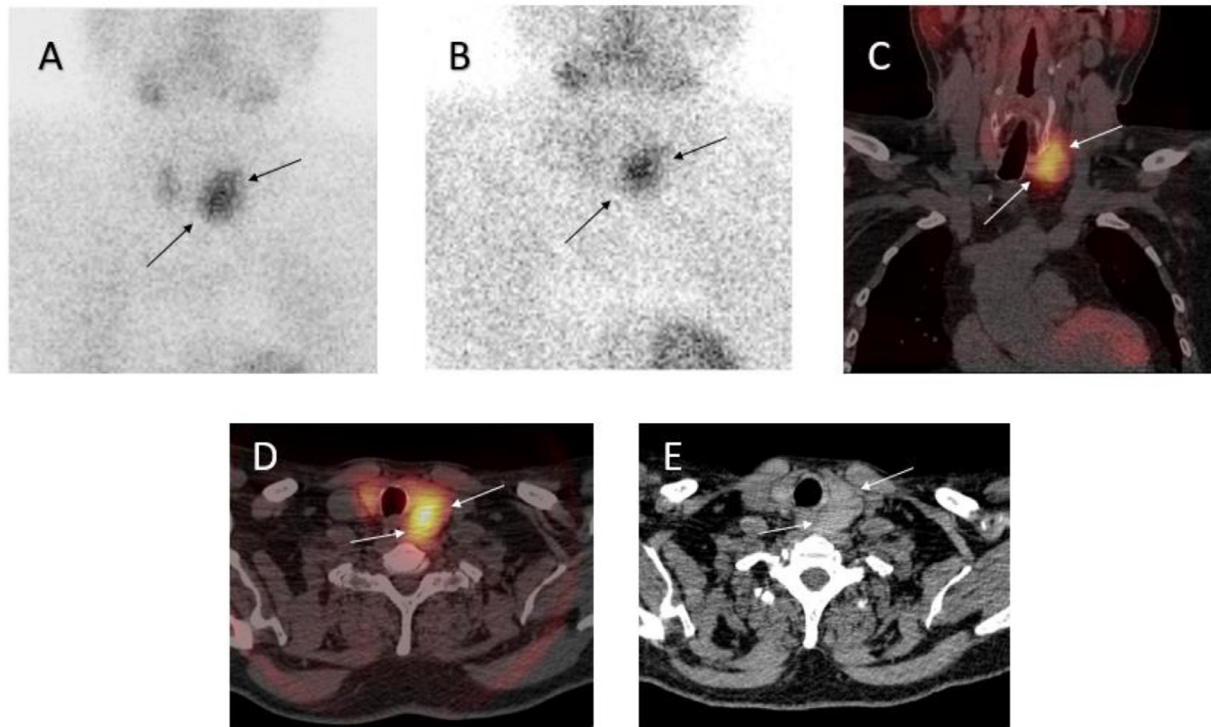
(A) Immediate ^{99m}Tc]Tc-Sestamibi SPECT show diffuse activity globally in the left thyroid lobe (arrows). (B) Delayed (2-hour) ^{99m}Tc]Tc-Sestamibi SPECT reveals persistent diffuse activity in the left thyroid lobe (arrows). (C) Delayed coronal and, (D) axial fused SPECT/CT images show persistent uptake in the posterior-caudal region of the left thyroid lobe, that could not be reliably separated from the thyroid (arrows). (E) Axial low-dose CT without contrast do not provide evidence of a parathyroid adenoma. There is no detectable difference in density between the anterior and posterior regions of the adenoma in the left thyroid lobe. These findings support the hypothesis of a thyroid adenoma rather than a parathyroid adenoma (arrows).
